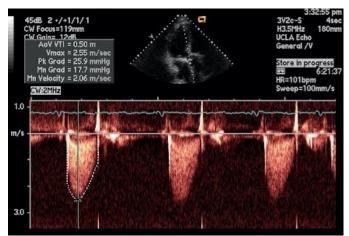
Repeat TTE at Six Months of Anticoagulation: Apical five-chamber view at six months reveals an aortic valve that is less stenotic with improving pressure gradients and velocity.
